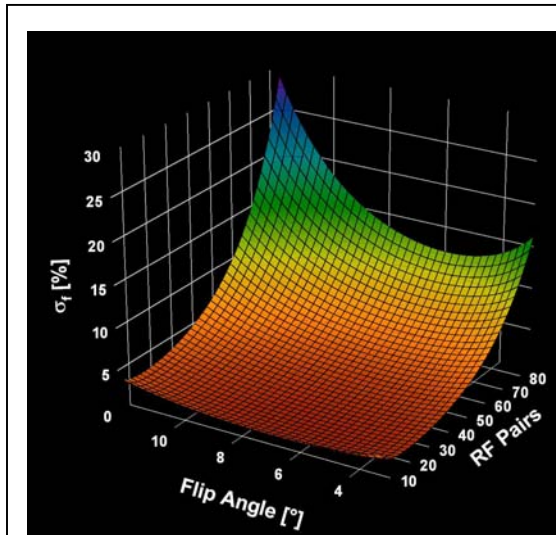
Predicted error in the XTC MRI depolarization maps as a function of the number of contrast-generating inversion RF-pulse pairs and the selected excitation flip angle.
